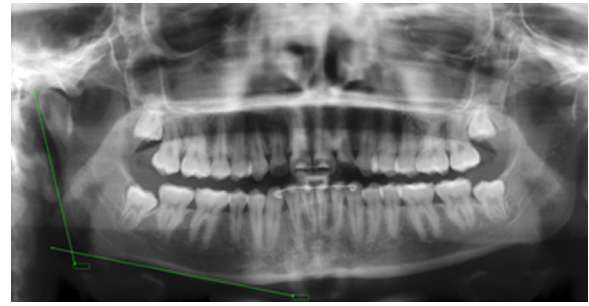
Measurement of the gonial angle in a digital panoramic radiograph used in this study.
